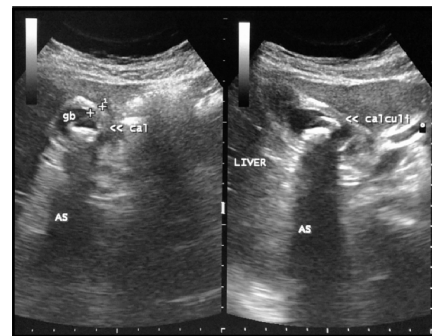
Sonographic Appearance of Acute Cholecystitis. Gall bladder Shows Multiple Calculi in its lumen along with Thickening and Edema of its wall.
